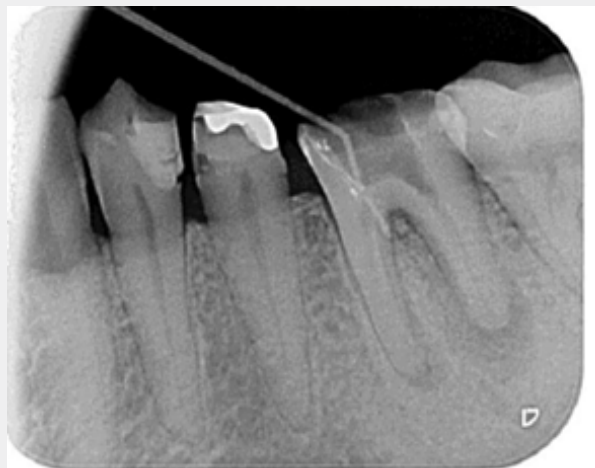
X-ray sealing quality control.
